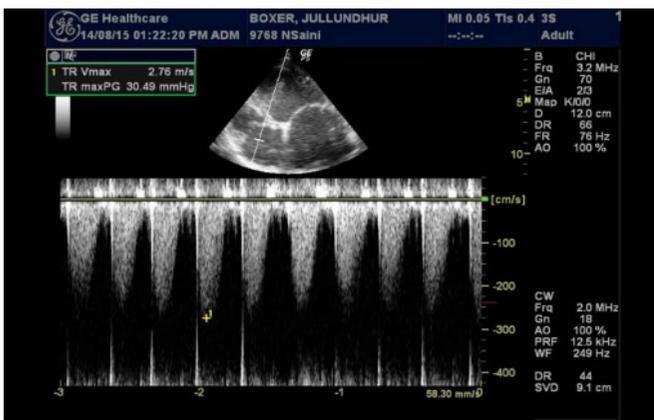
Left apical four-chamber view with continuous-wave doppler at tricuspid valve measuring the tricuspid flow regurgitant velocity of 2.76 m/sec.
